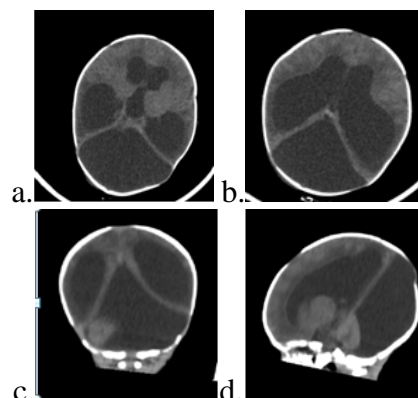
Computed tomography demonstrates the hydrocephalus and hypoplasia of cerebellum and enlarged fourth ventricle: a,b: hydrocephalus, c,d: hypoplasia of cerebellum, d: enlarged fourth ventricle
